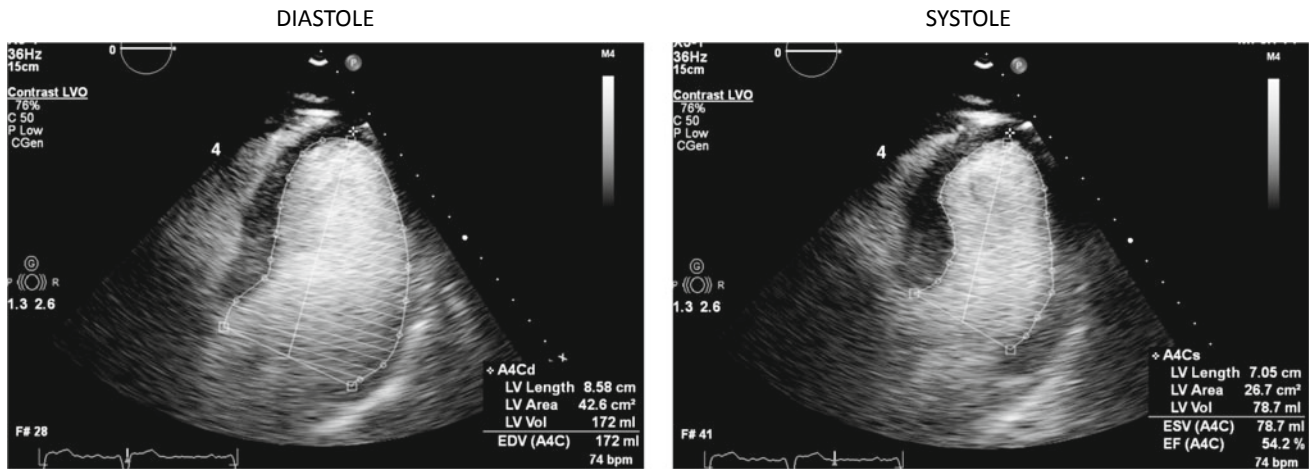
Pre-treatment Echocardiogram in March 2020, EF was 54%, low normal
